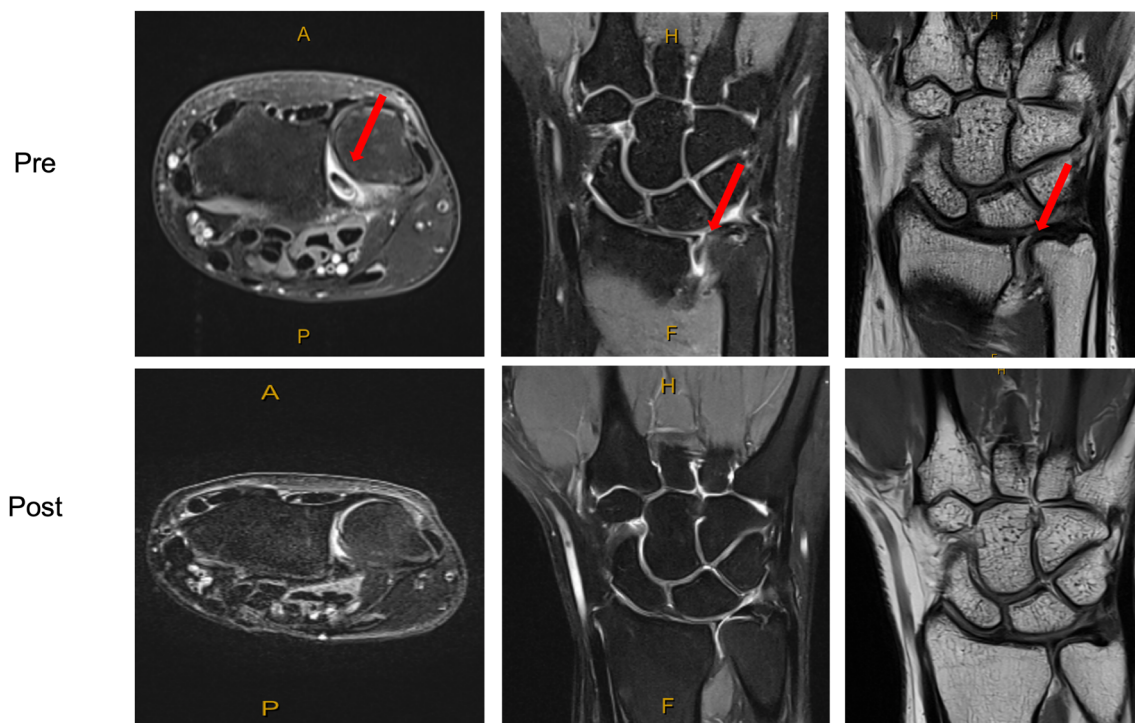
Preoperative (Top row) and postoperative (bottom row) MRI demonstrating central TFCC tear with incarceration in the DRUJ. Solid red arrow indicating interposed tear.
